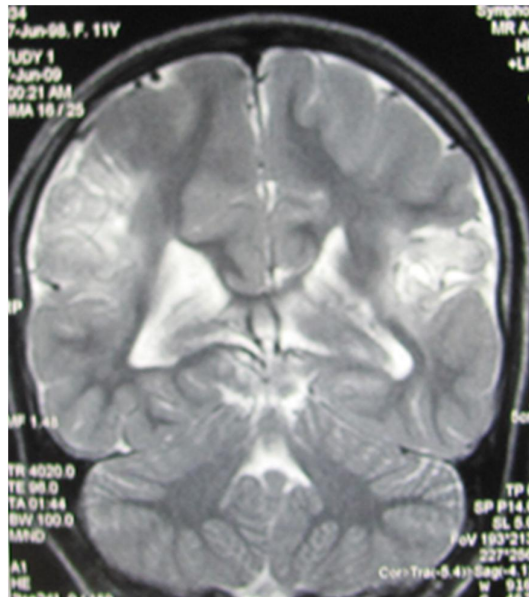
MRI Brain T2 Coronal showing bilateral Perisylvian HIE
